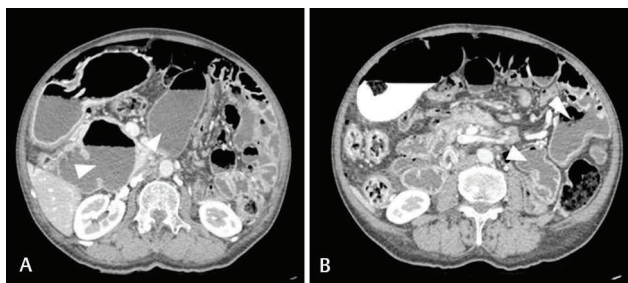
(A) Axial CECT sections of abdomen with neutral oral contrast in venous phase, show large diverticula (arrowheads) arising from second and third part of duodenum, (B) shows multiple jejunal diverticula (arrowheads). CECT, contrast-enhanced computed tomography.
